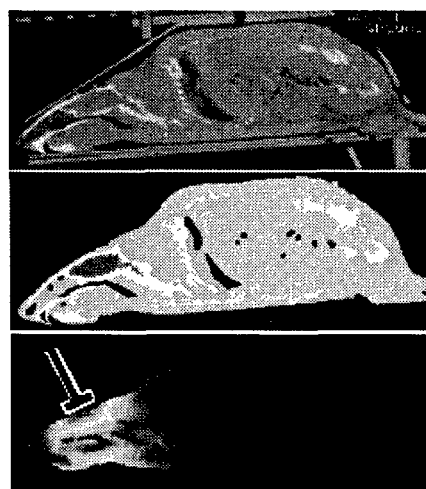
Exposure assessment of the setup in Fig. 8. CT image (upper), heterogeneous numerical model (middle), calculated SAR distribution (lower).
